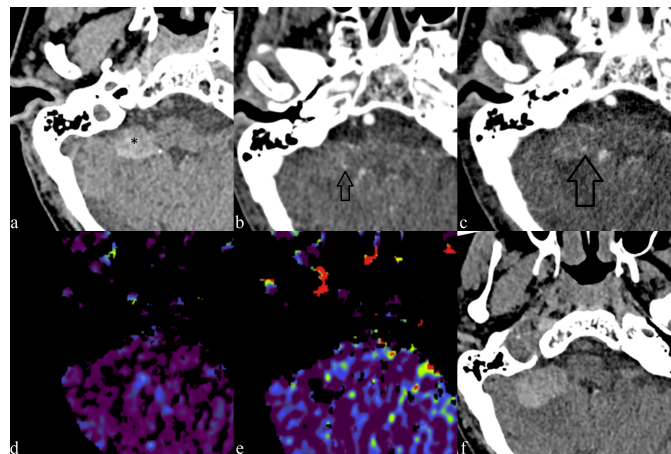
A patient with progressed right cerebellar hematoma. Non-contrast initial CT (a); right cerebellar parenchymal hematoma (*). CTA (b) and CTP (c); spot signs (empty black arrows) in the hematoma. Permeability (d) and CBV (e) maps derived from CTP; no visible change in and around hematoma. Follow-up CT (f); horizontally increased size of hematoma.
